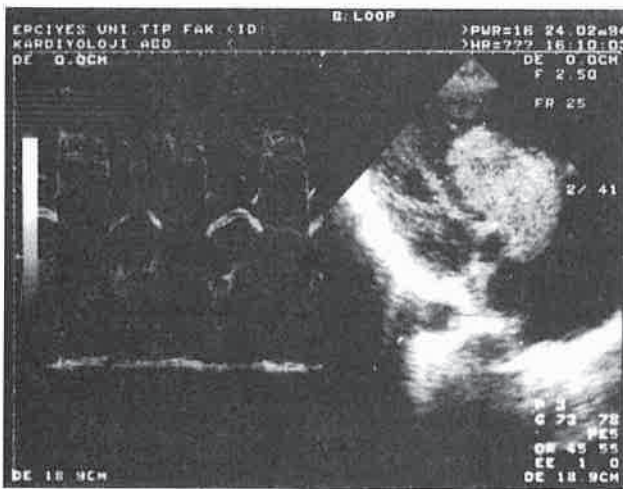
Echocardiographic view of a large right atrial myxoma during diastole.
